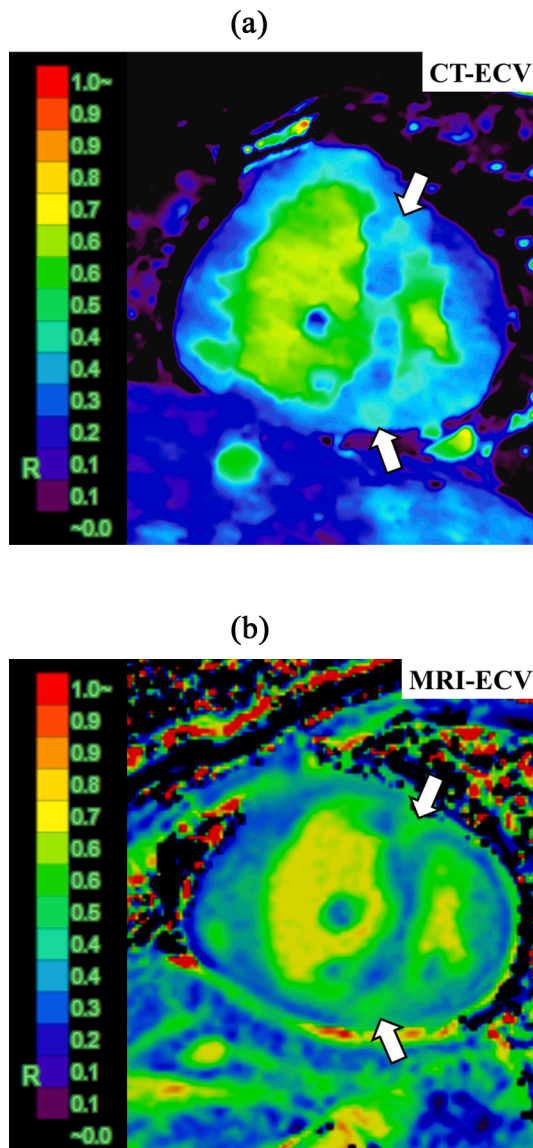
A representative case. (A) Computed tomography (CT)-derived extracellular volume (ECV) and (B) cardiac magnetic resonance imaging (MRI)-derived ECV in a 38-year-old woman with idiopathic pulmonary arterial hypertension. CT-ECV and MRI-ECV images show significantly elevated myocardial ECV, especially in the anterior and posterior RVIP (arrows). The values of ECV at the anterior and posterior right ventricular insertion point were 48.9% and 46.6%, respectively, for CT-ECV, and 47.9% and 44.0%, respectively, for MRI-ECV. CT-derived ECV and cardiac MRI-derived ECV quantifications were comparable.
